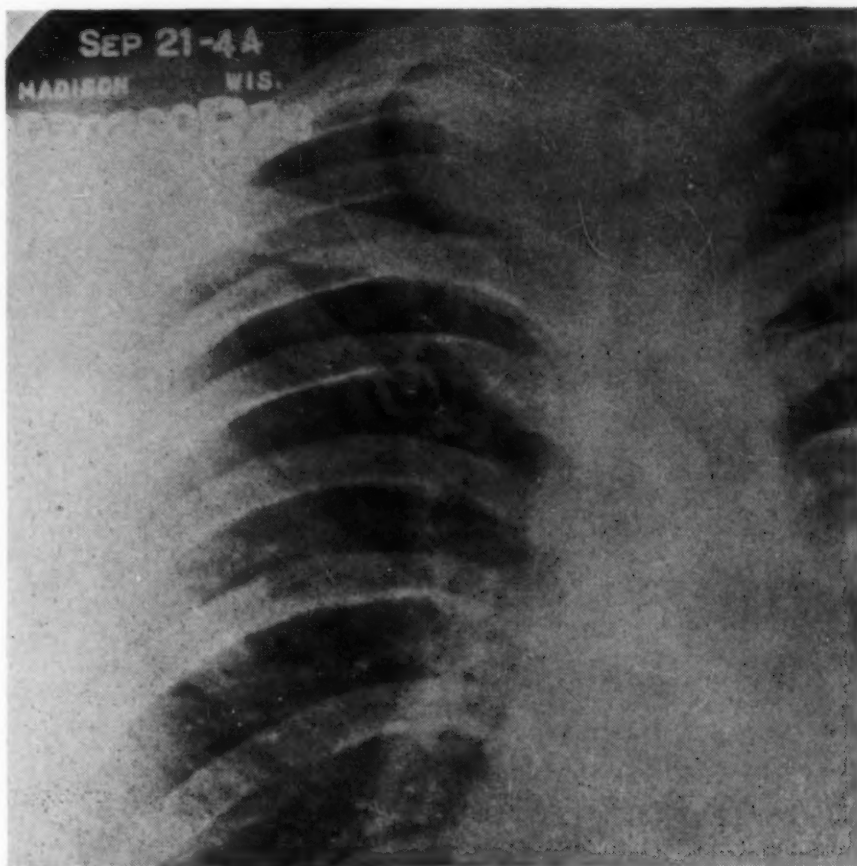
Case 4: Final roentgenogram of 9-21-44 (Seven years after A). No change in size.
